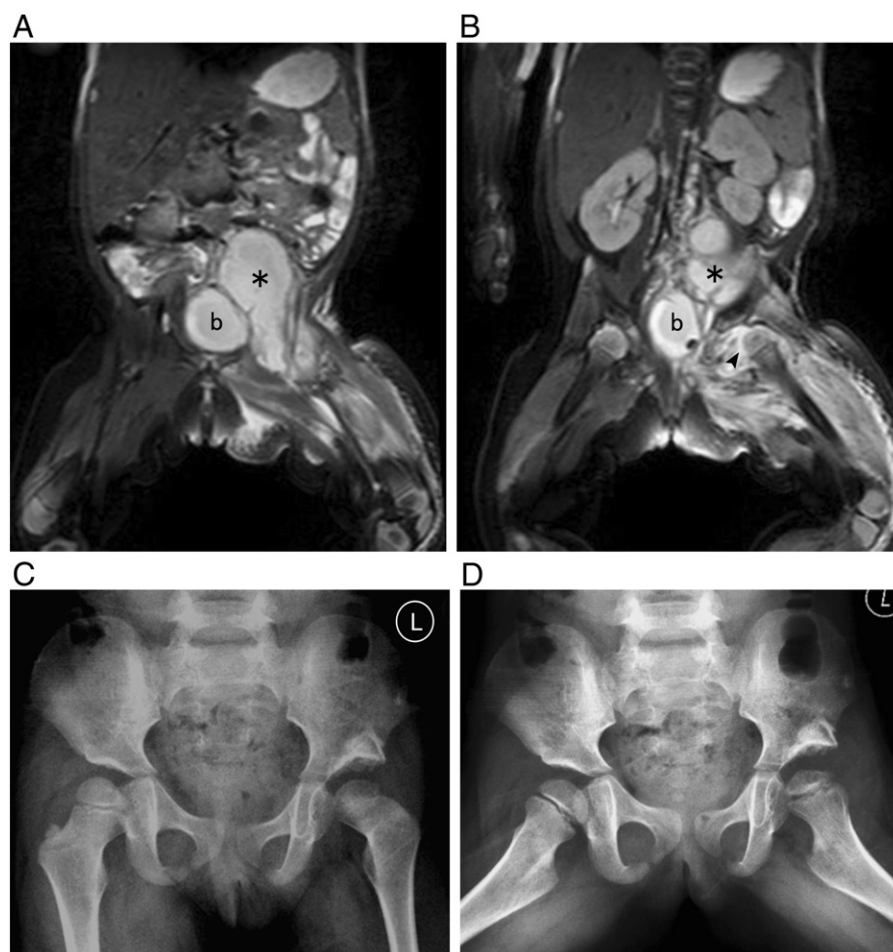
T2-weighted series of the MRI showing the psoas abscess next to left hip (A) and effusion and subluxation of the hip (B) in case 1 (asterisk indicates psoas abscess; b, bladder; arrow head, hip effusion). (C and D) X-ray plain films showing sclerotic acetabular roof and growth disturbance of the left proximal femur at 3 years of follow-up of case 1.
